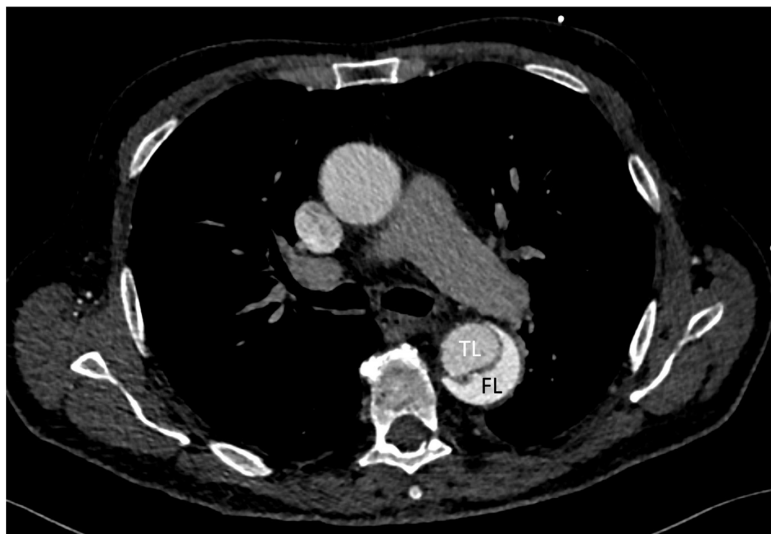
Computed tomographic angiography showing aortic dissection with true lumen (TL) and false lumen (FL)
